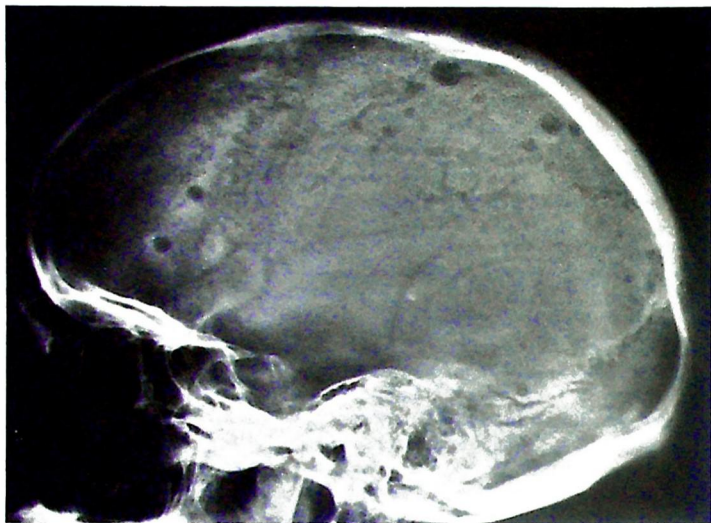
Skull radiograph showing multiple lytic ("punched out") lesions in a patient with multiple myeloma.
